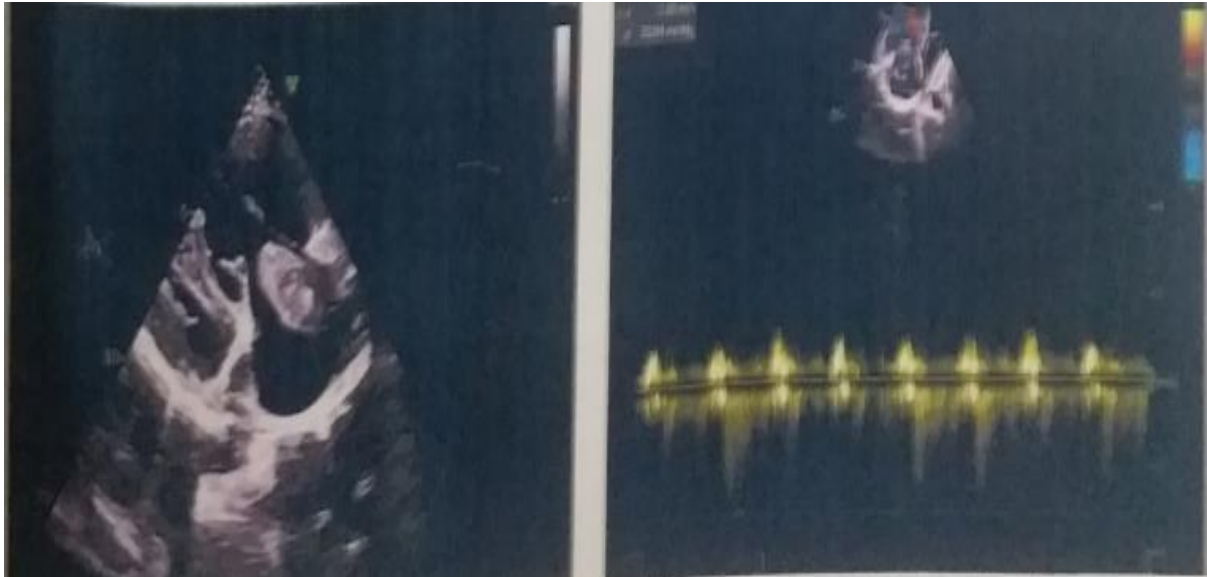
Two-dimensional echocardiography and colour doppler showing 3.5x3x2 cm attached mass in right atrium 14 mm away from tricuspid valve.
